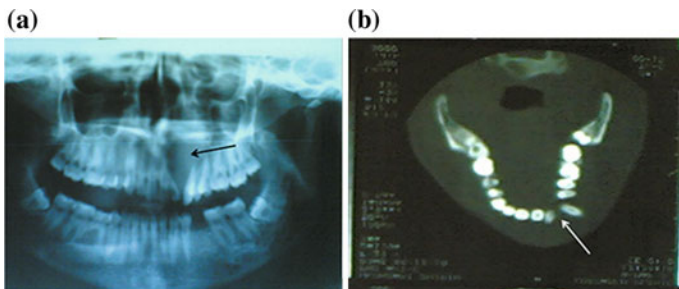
Radiographic view: a Panoramic view: a relatively well-defined mixed radiolucency was seen. b CT scan view: left maxillary teeth were displaced by destructive mass. Basir Shabestari et al. (2012), with permission
